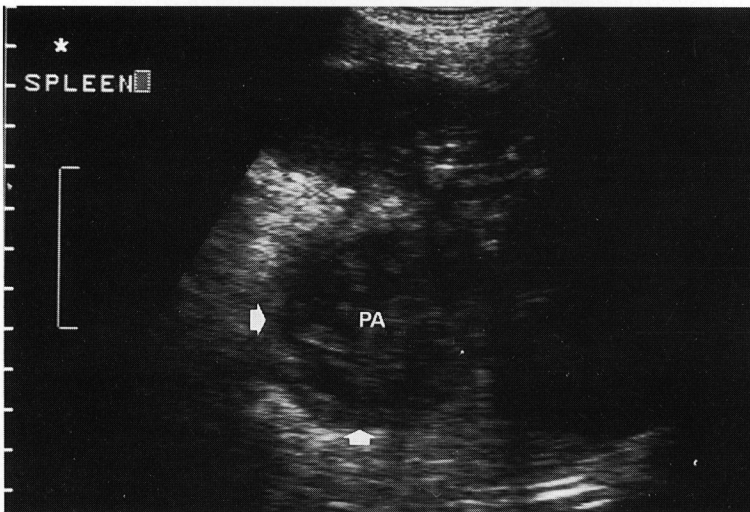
Abdominal ultrasonography shows a well defined round hypoechoic mass (→) in the tail of pancreas. PA : Pseudo aneurysm
